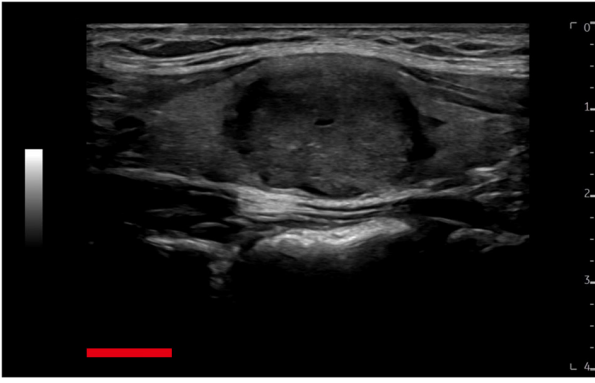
Ultrasound image. An ultrasound of the right thyroid lobe revealed a solid, well-defined hypoechoic nodule (scale bar, 1 cm).
